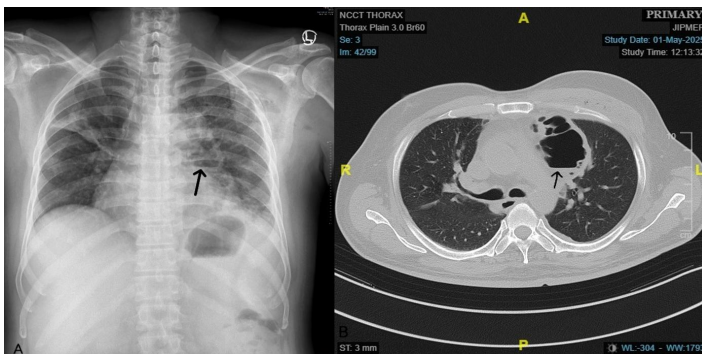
A) The chest radiograph in posteroanterior view now demonstrates air-fluid level at the left side of the pneumomediastinum (arrow), suggesting mediastinal abscess and right middle zone fibrotic bands. B) Repeat high-resolution computed tomography in axial view now shows left-sided mediastinal collection with air-fluid level within it.
